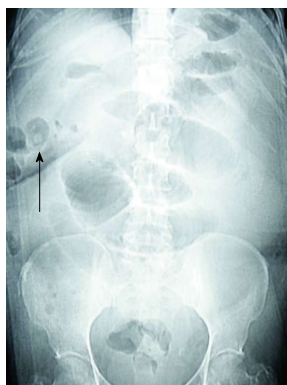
Plain abdominal radiograph showing dilated small bowel loops and a high density endoluminal image suggestive of a gallstone (arrow). No pneumobilia is visualized.
